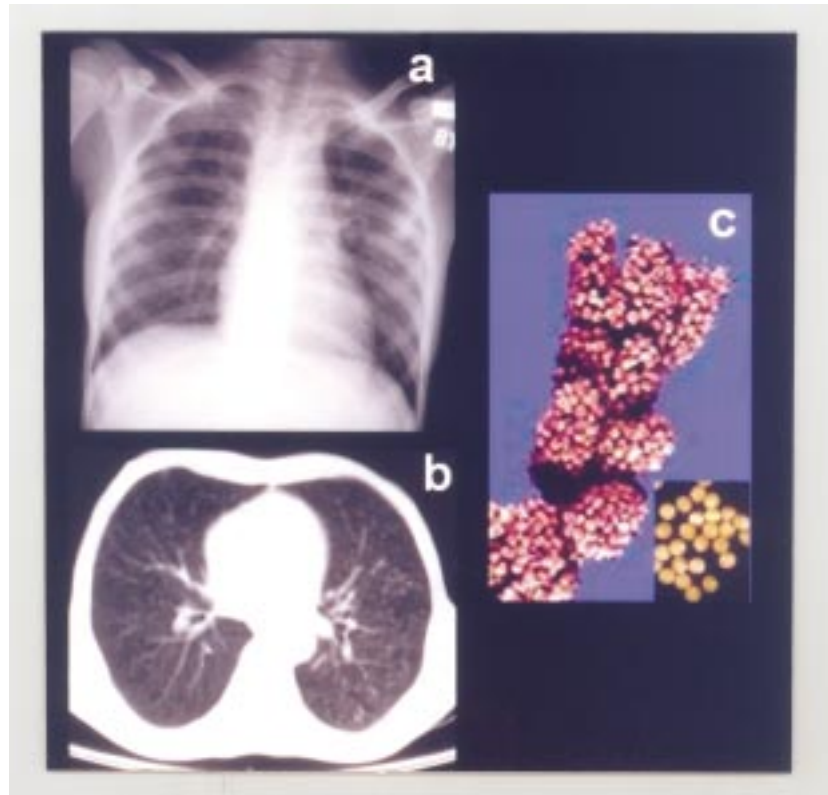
Chest radiograph (postero-anterior view) showing classical miliary pattern (a). Contrast enhanced CT scan of the chest (b) showing classical miliary pattern. Branching nodular (2 to 3 mm) and linear opacities resulting in a tree-in-bud appearance can also be discerned. These nodules resemble millet seeds (c).
